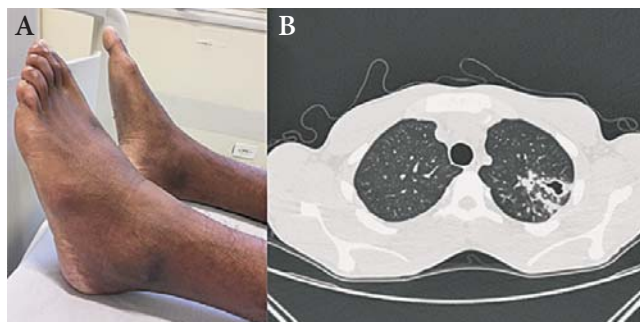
In (A), the patient's swollen ankles at presentation. In (B), typical lesion seen on chest CT.
